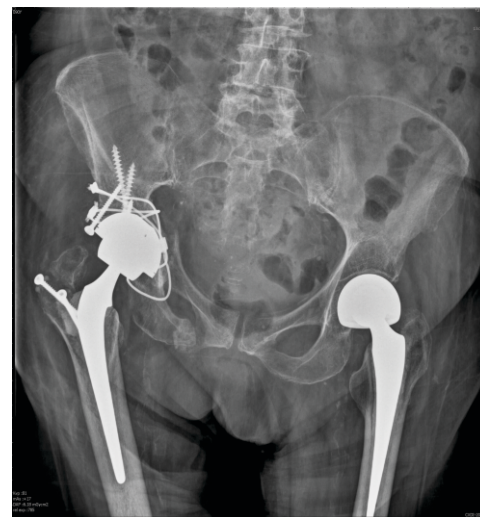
b: Radiographic evaluation of the right hemipelvis 4 months after surgery. Good signs of fracture healing without migration of the acetabular component.
